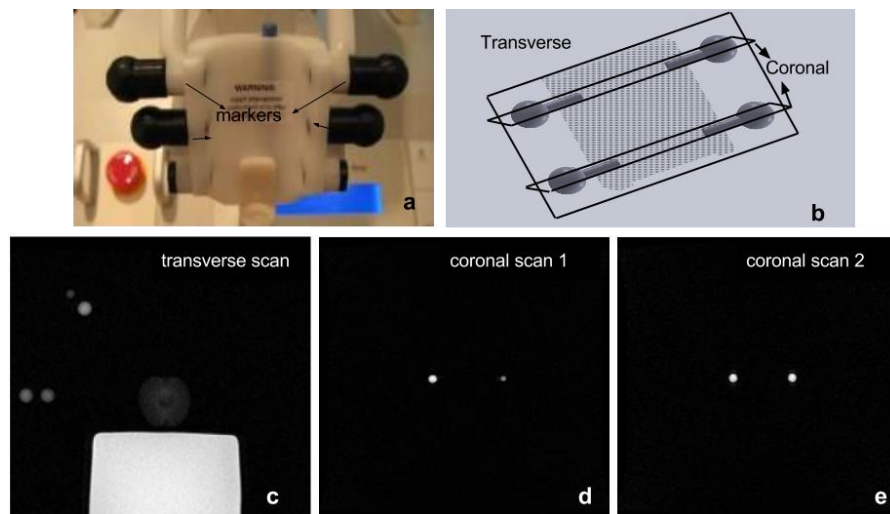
Passive method of confirming the position of robotic arm. (a) The four ball-shaped markers are filled with a Gadolinium based contrast agent; (b) The MR scan orientation of the robot markers for its position registration in the MR frame reference frame; (c), (d), (e) MR images of the four markers, the transverse scan plane has to contain all four markers, and each of the coronal scan planes has to contain two of them at the same height.
